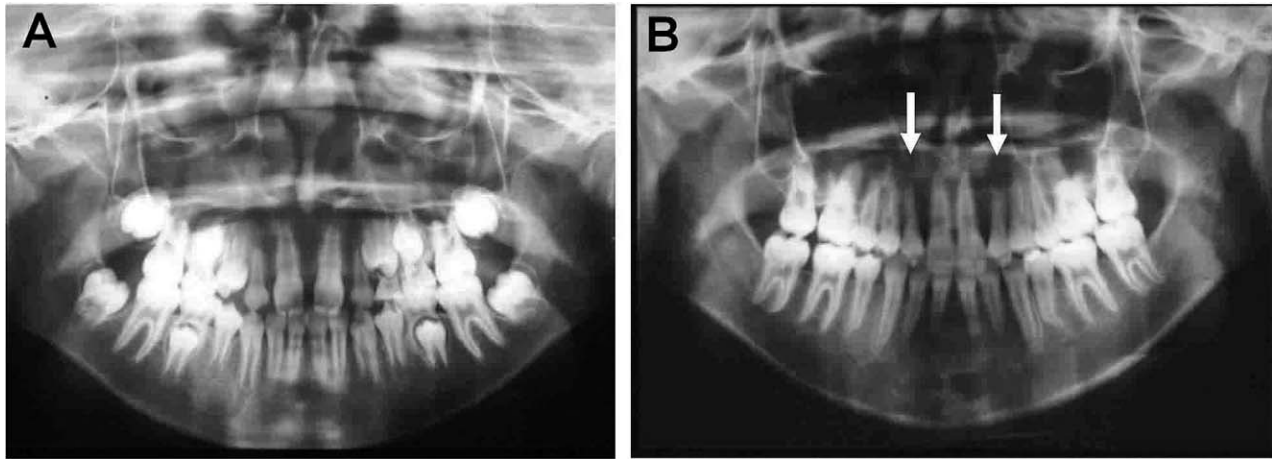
Panoramic radiographs at pretreatment and posttreatment.
